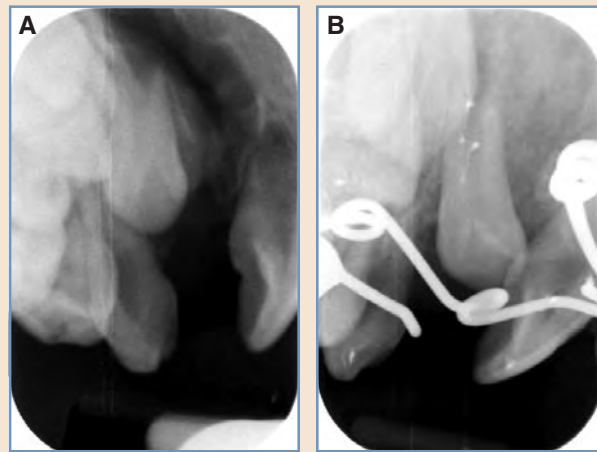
A, An apical dental radiograph showing a typical unilateral alveolar cleft defect before treatment with adjacent deciduous and permanent teeth on either side of the cleft bone defect. B, An apical dental radiograph showing the same unilateral alveolar cleft region after treatment with our preferred technique of minimal access ICBG and allograft bone graft. Note the complete obliteration of the cleft bone defect and replacement with mature bone that has supported eruption of the adjacent teeth. This is a typical Enemark 1 result.
